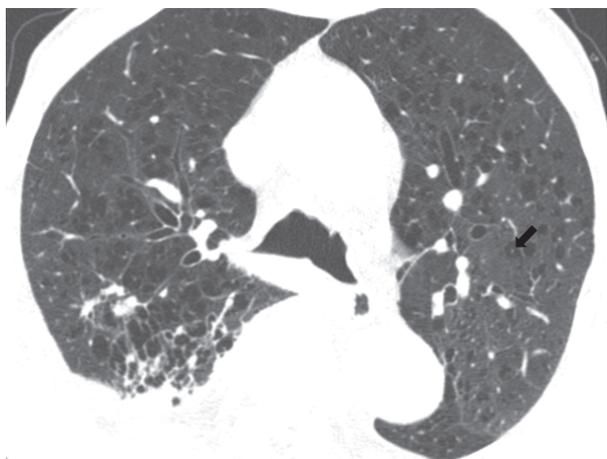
Axial HRCT section in lung window shows well defined lucent areas with no definite wall. Central dot sign(black arrow) is seen in some of the areas in left lung, suggesting centriacinar emphysema
